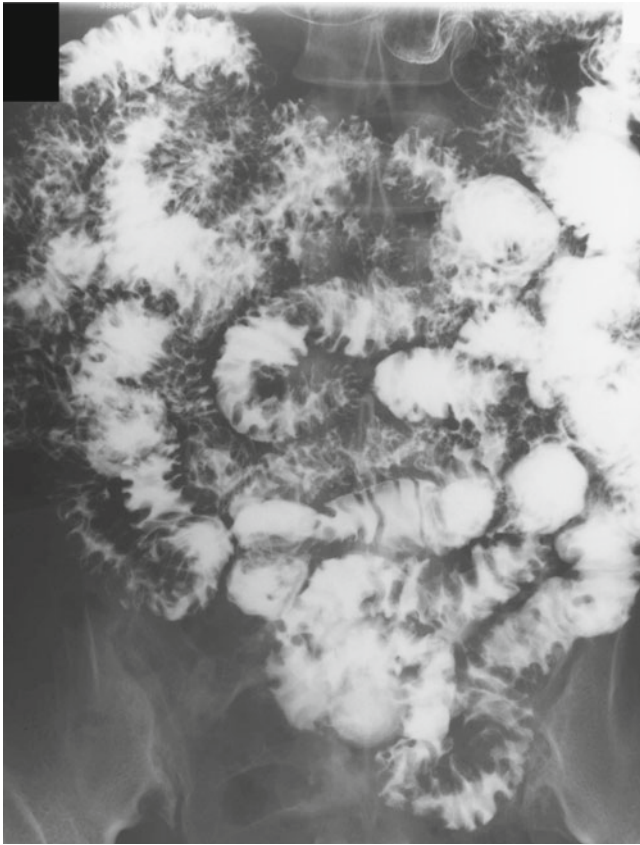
Radiography showed widespread irregular swelling of the folds in the small intestine
